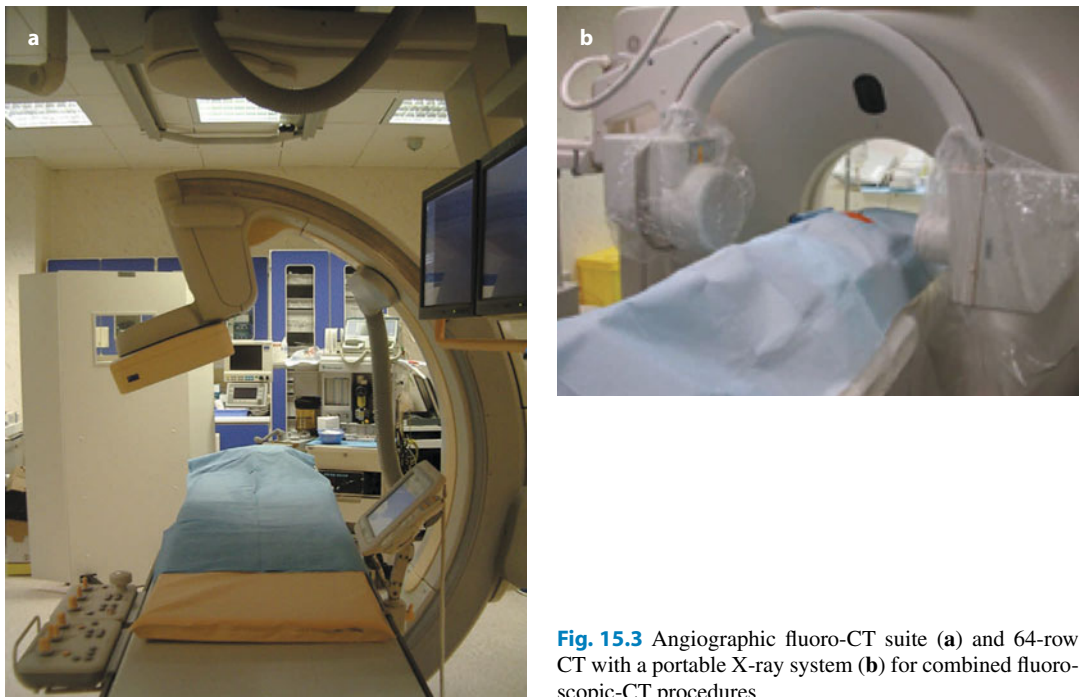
Angiographic fluoro-CT suite (a) and 64-row CT with a portable X-ray system (b) for combined fluoro-CT procedures
